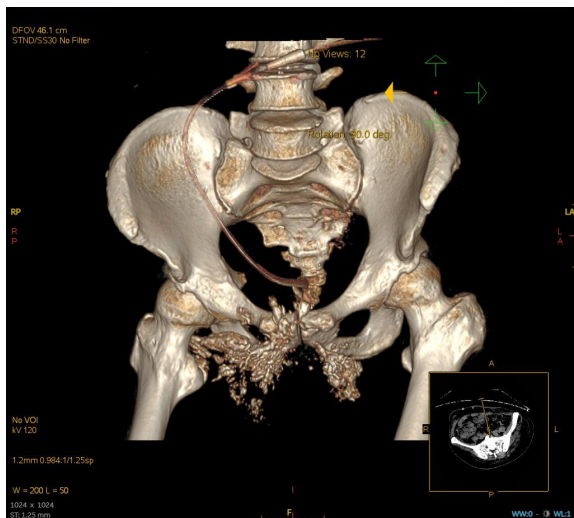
CTU, bone metastasis and osteonecrosis. CTU, computed tomography urography.
